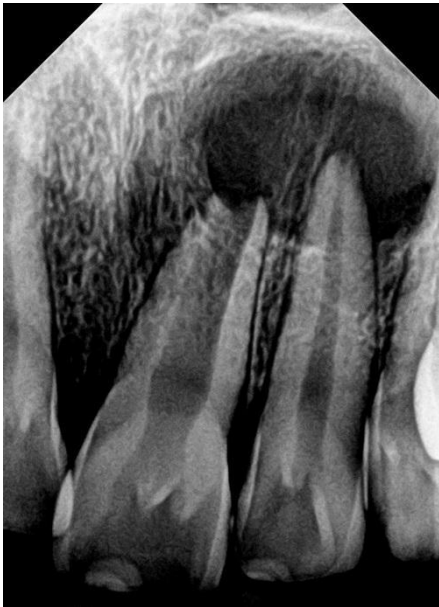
Digital X-ray before treatment - Periapical radiograph showing a significant periapical radiolucency associated with teeth #21, #22, And: Tooth #21 with an open Apex
